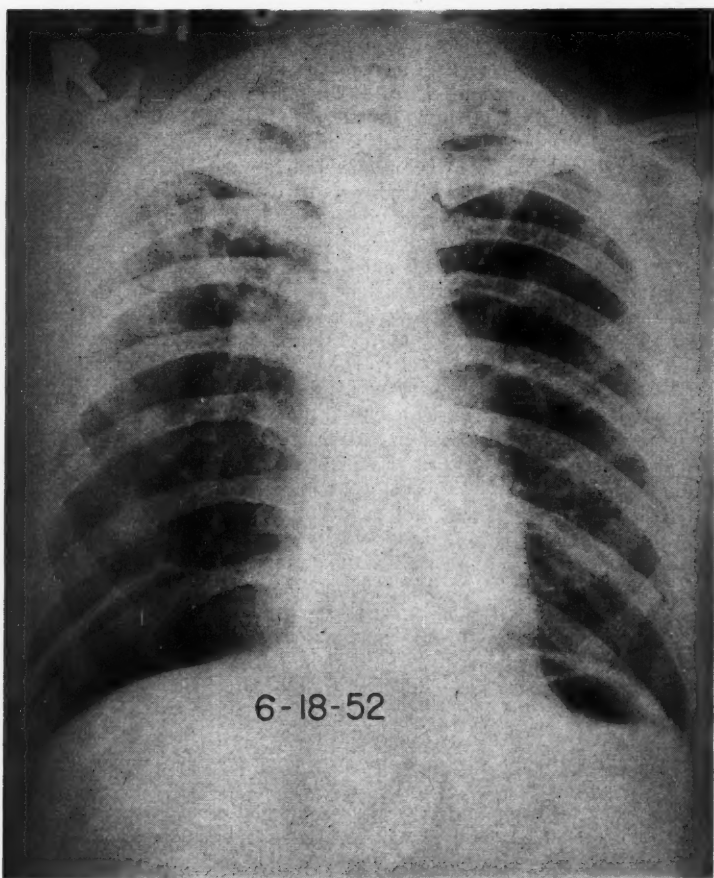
Chest roentgenogram taken three weeks after induction of pneumoperitoneum. Note abnormal thinning of medial half of right dome of diaphragm.
